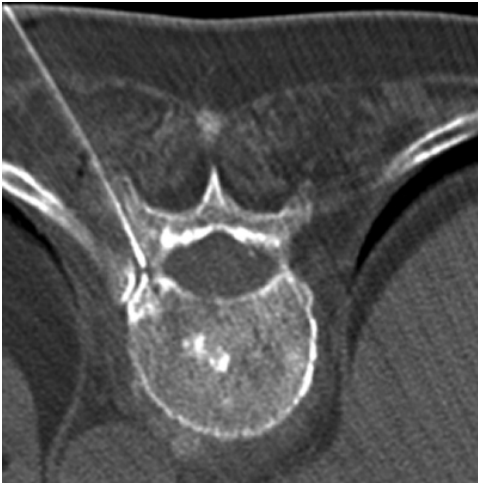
22-gauge spinal needle placement under CT control.
